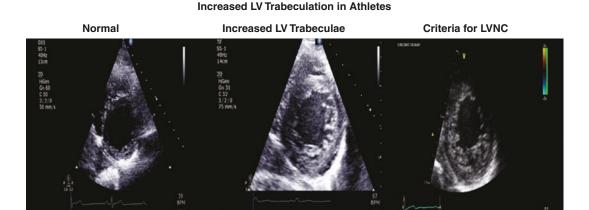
Increased LV trabeculations on echocardiography in athletes demonstrating the challenge of distinguishing between normal and LVNC
